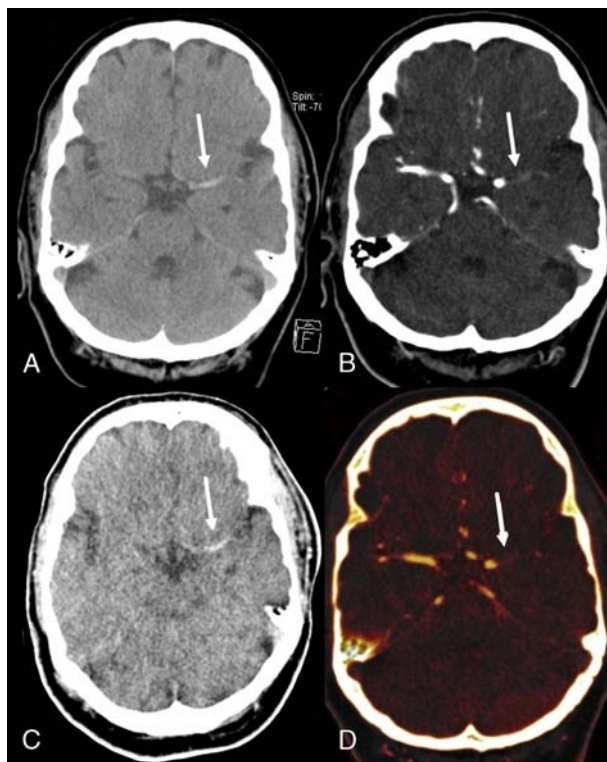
True noncontrast (A), CTA (B), VNC (C), and iodine (D) images of a 71-year-old male patient with acute ischemic stroke. C and D are postprocessed images from B. The HAS is clearly visible in both A and C (arrow). Note the vessel occlusion with the missing iodine contrast (arrow) in the CTA (B) and in the iodine (D) images compared with the contrast in the vessel on the contralateral side.
